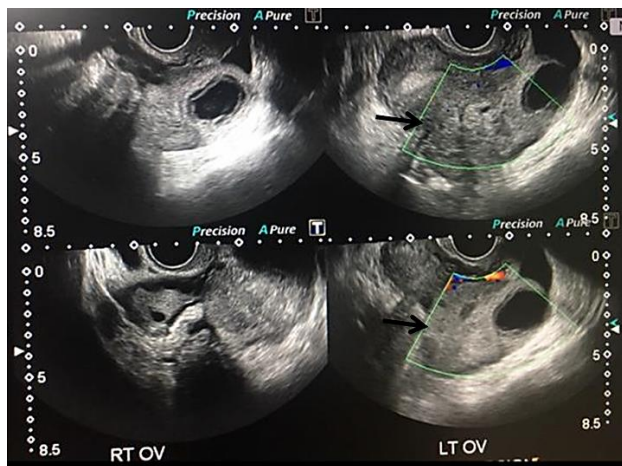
Right ovary is normal. Left ovary is enlarged with a cyst. No blood flow seen on doppler evaluation - Left ovarian torsion (black arrow)
